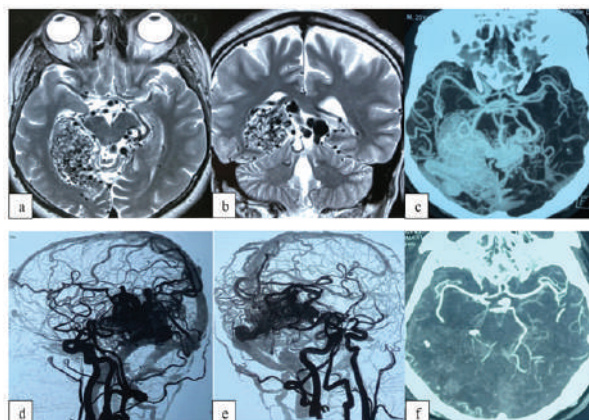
A 26-year-old man with right medial temporal AVM. Axial (a) and coronal (b) T2W-MRI demonstrated a tangle of multiple dot like and branching flow voids occupying right sided medial lobe, posteromedial to the temporal horn. (c) CTA showing a compact nidus of about 7x6.5x 5 cm in diameter. TRCTA and lateral (d) and oblique (e) views show arterial feeders from multiple branches of the right middle cerebral artery and posterior cerebral artery. The AVM has a deep venous drainage into the basal vein of Rosenthal (Spetzler-Martin grade 4). (f) Follow up CTA demonstrated complete resection of the AVM. Here, AVM: arteriovenous malformation; TRCTA: time-resolved computed tomography angiogram; T2W-MRI: T2 weighted magnetic resonance imaging.
